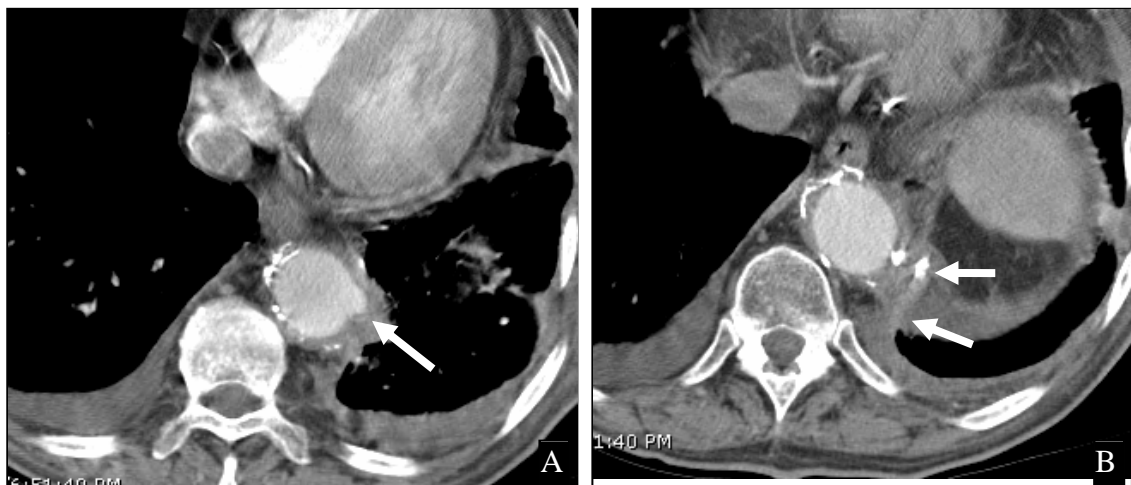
Patient had CT scan worrisome for descending aortic ulcer, A, Cobrahead graft(arrow) could be mistaken for aortic ulcer Slightly caudal, B, shows course of graft.
